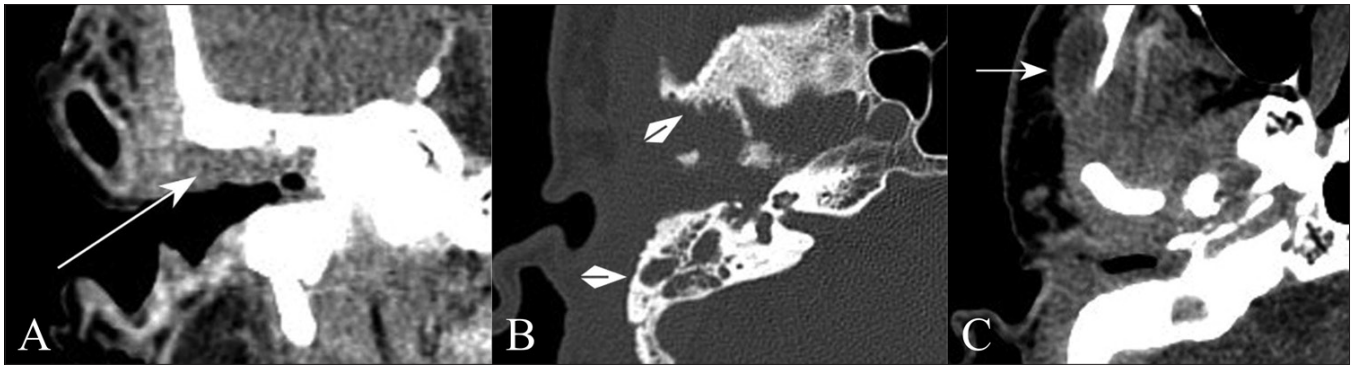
(A-C): Malignant otitis externa: coronal contrast-enhanced CT scan (A) shows soft tissue thickening of the EAC (arrow). Axial HRCT image (B) shows irregularity of the right TM joint (arrowhead) and mastoid (arrowhead). Axial contrast-enhanced CT scan (C) shows a temporalis abscess (arrow)
